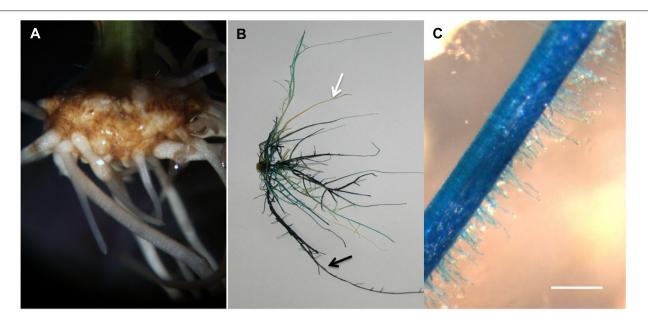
Soybean transgenic roots and root hairs generated in the ultrasound areoponic system; (A) transgenic roots emerging from the callus 10 days after *Agrobacterium rhizogenes* inoculation;
